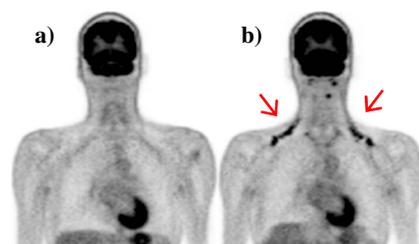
Cold-activation of supraclavicular BAT (red arrows) demonstrated by ¹⁸F-FDG PET. Coronal single slice images show minimal ¹⁸F-FDG uptake in a) thermoneutral (24°C), and b) cold (16°C) scans performed on the same subject.
